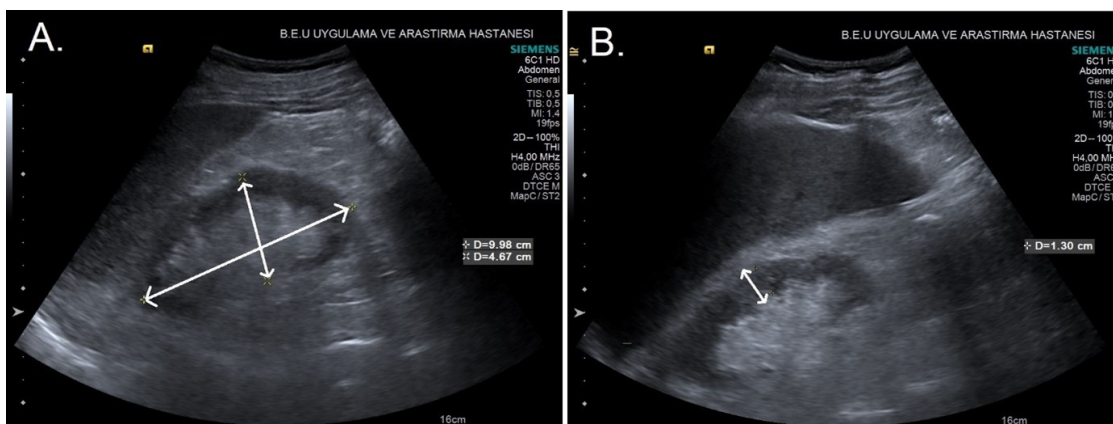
Measurement of kidney size and renal cortical thickness by renal ultrasonography. A, Long and short axis dimensions of the kidney. B, Renal cortical parenchymal thickness measurement.
